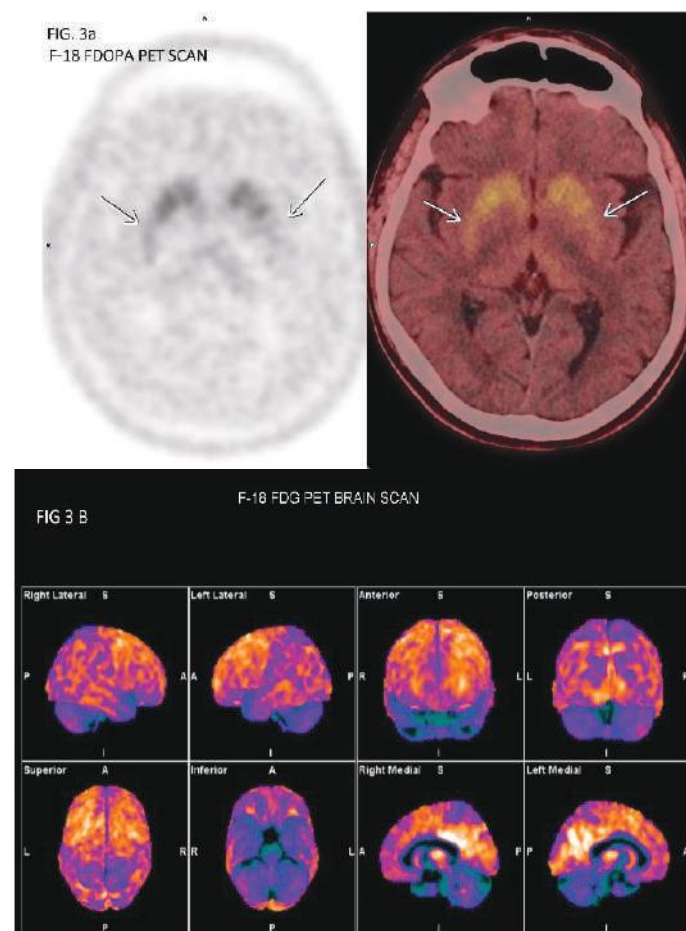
F-18 FDOPA PET CT scan (fig. 3a) showing asymmetrically reduced radiotracer uptake in bilateral basal ganglia (left more than right) with putamen affected more than caudate nucleus. FDG PET scan (fig. 3b) showing mild diffuse hypometabolism in bilateral temporo-parietal regions of the brain with preserved uptake in the bilateral basal ganglia, suggestive of Idiopathic Parkinson's disease (IPD).
